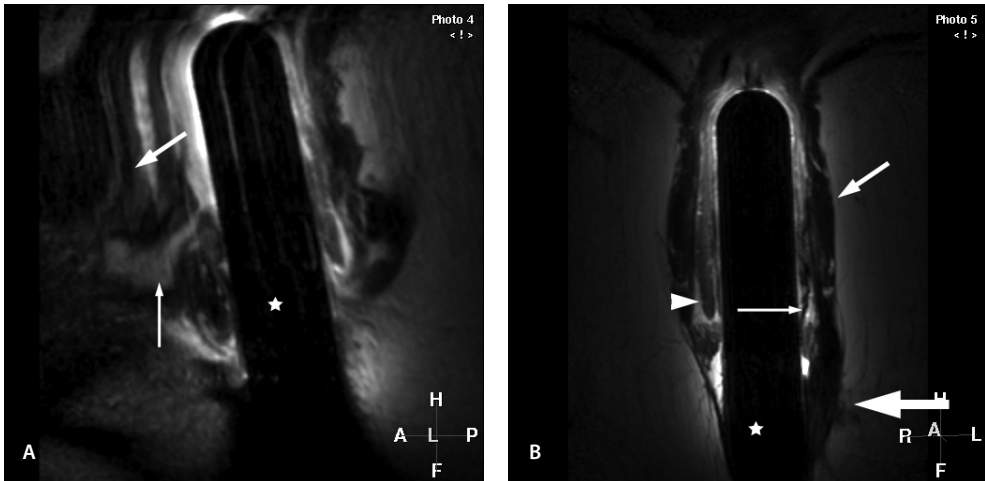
Anovaginal fistula with sphincter damage. (a) Sagittal T2-weighted fast SE MR image (2,443/100) shows high signal intensity anovaginal fistula (thin straight arrow) between the anal canal and the posterior wall of the vagina (curved arrow). The endoanal coil (★) is also shown. (b) Coronal T2-weighted fast SE MR image (2,443/100) shows thickening and scarring of the external anal sphincter (thick straight arrow) on the left side. The internal sphincter shows thinning on the left side (thin straight arrow), whereas the sphincter remains healthy on the right side (arrowhead). The puborectal muscle (curved arrow) and endoanal coil (★) are also shown.
